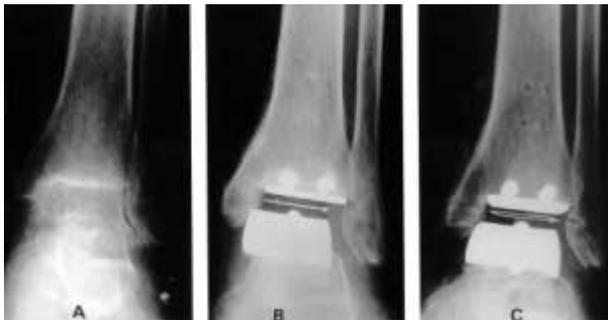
Radiographs showing improper placement of a STAR prosthesis and a peroperative complication: (a) pre-operative film; (b) postoperative film showing a medially shifted talar component; (c) oblique view showing intra-operative cut into the fibula.
